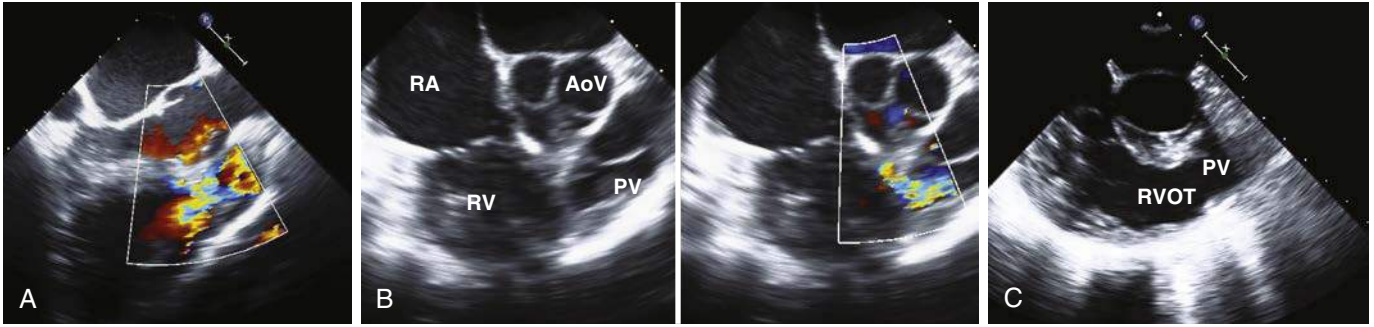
A, Preoperative transesophageal echocardiography (TEE) midesophageal view at the long axis of the right ventricular outflow tract (RVOT). In this systolic frame, note the flow acceleration (arrow) with color Doppler beginning in the subvalvar region of the RVOT. B, Preoperative, midesophageal color compares TEE view taken during diastole showing the thickened muscle bundles in the RVOT. C, Postoperative midesophageal image after removal of the obstructing muscle bundles in the RVOT showing no residual obstruction. RV, right ventricle.
